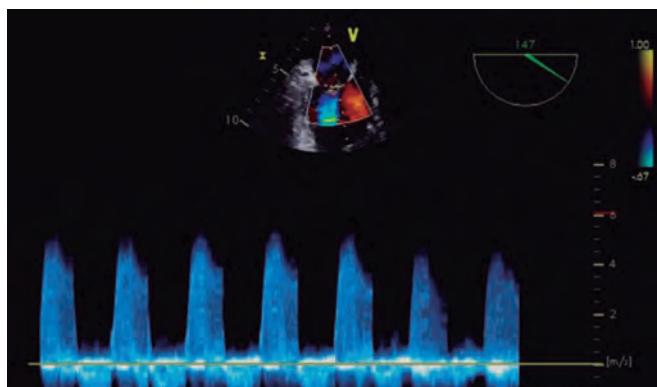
Transesophageal echocardiography image. Doppler image of a severe mitral regurgitation single jet. Its shape is triangular and density is high, suggestive of severity. Reproduced with permission from López-Optiz, and Moreno-Urrutia.³⁰
